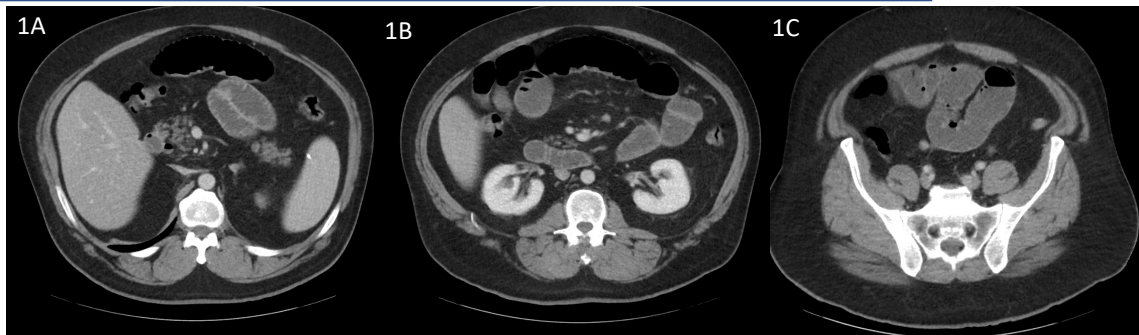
1B, 1C: Abdominal CT showing dilated loops of small bowel, measuring up to 4.1 cm in the left lower quadrant.
